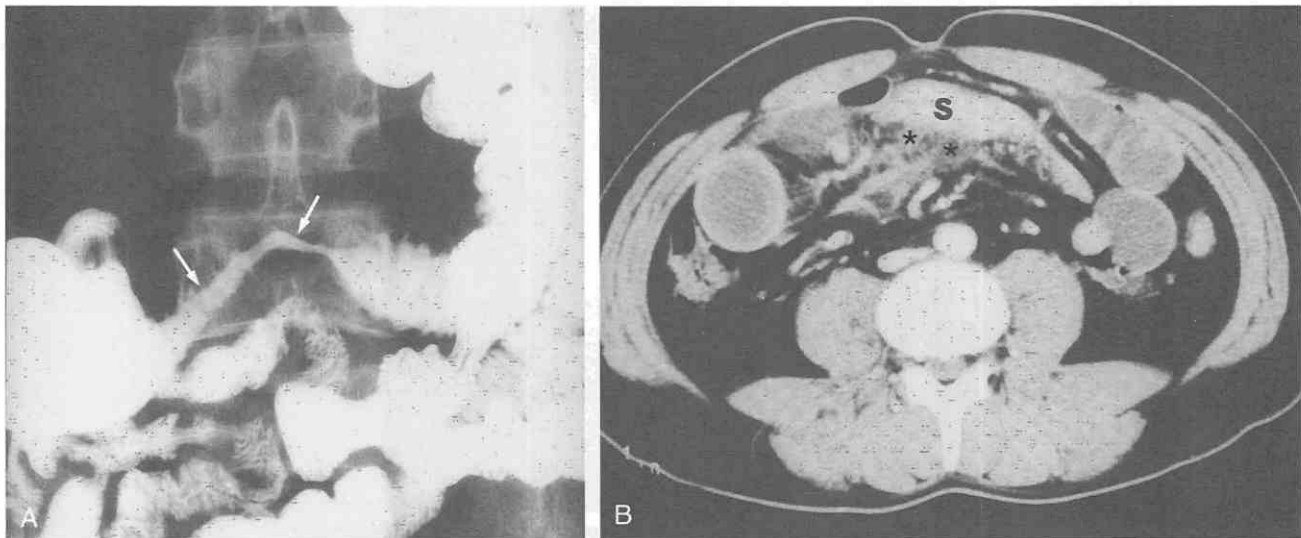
Post-traumatic intestinal stenosis following blunt abdominal trauma 1 month before. *A*, Small-bowel follow-through shows short segment of tapered, circumferential luminal narrowing (arrows) of the distal jejunum along with thickened folds and ulcerations. *B*, CT scan shows marked contrast enhancement of the thickened bowel wall (arrows). Regional mesenteric vascular engorgement and haziness (asterisks) are also seen. (From Ha HK, Rha SE, Kim AY, et al: CT and MR diagnoses of intestinal ischemia. *Semin Ultrasound CT MRI* 21:40-55, 2000.)
